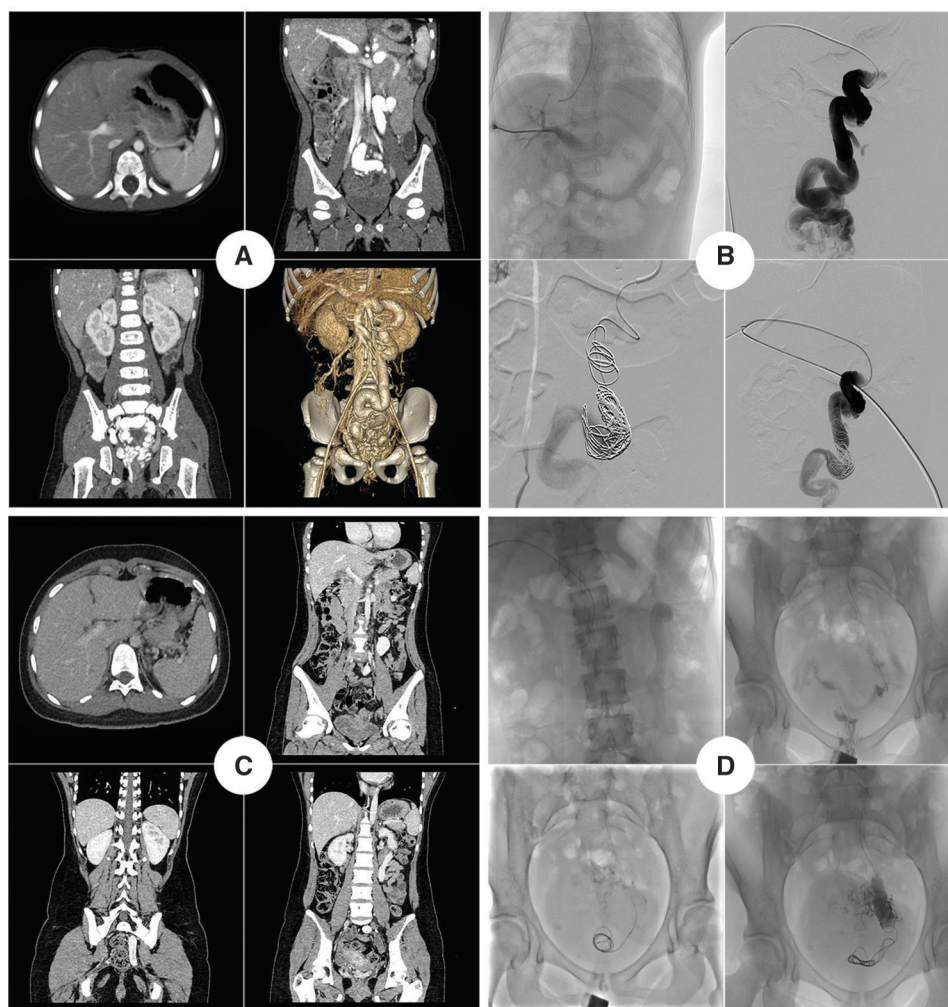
The images of contrast-enhanced abdominal computed tomography (CT) and operation procedures of ultrasound-guided percutaneous transhepatic interventional closure. (A) Contrast-enhanced abdominal CT with three-dimensional reconstruction in Case 1 shows an almost normal portal vein with a dilated inferior mesenteric vein connection between the splenic vein and the right internal iliac vein and obvious rectal varices in the pelvis. (B) Operation procedures in Case 1. Percutaneous transhepatic portal vein puncture was performed under ultrasound guidance, followed by insertion of a 4 French sheath. Portal pressure was measured at ~ 11 mmHg. After angiography confirmed shunt blood flow to the right internal iliac vein, four interlocking coils were inserted anterogradely into the inferior mesenteric vein to embolize the shunt. Repeat angiography showed that the shunt blood flow velocity was significantly slowed. Portal pressure was measured again at ~ 15 mmHg and recovered to 12 mmHg after 20 minutes. (C) Contrast-enhanced abdominal CT in Case 2 shows an almost normal portal vein with a dilated inferior mesenteric vein communicating with the left internal iliac vein. (D) Operation procedures in Case 2. The patient underwent anterograde angiography of the inferior mesenteric vein after percutaneous transhepatic puncture of the portal vein under ultrasound guidance, which was confirmed to be connected to the bilateral internal iliac vein; thus, the diagnosis of Type 2 Abernethy malformation was considered. Then, three interlocking coils were inserted anterogradely along the portal vein to the distal end of the inferior mesenteric vein to embolize the shunt. Repeat angiography showed that the shunt blood flow velocity was significantly slowed. The portal pressure was measured at ~ 24 mmHg and recovered to 21 mmHg after 20 minutes.
